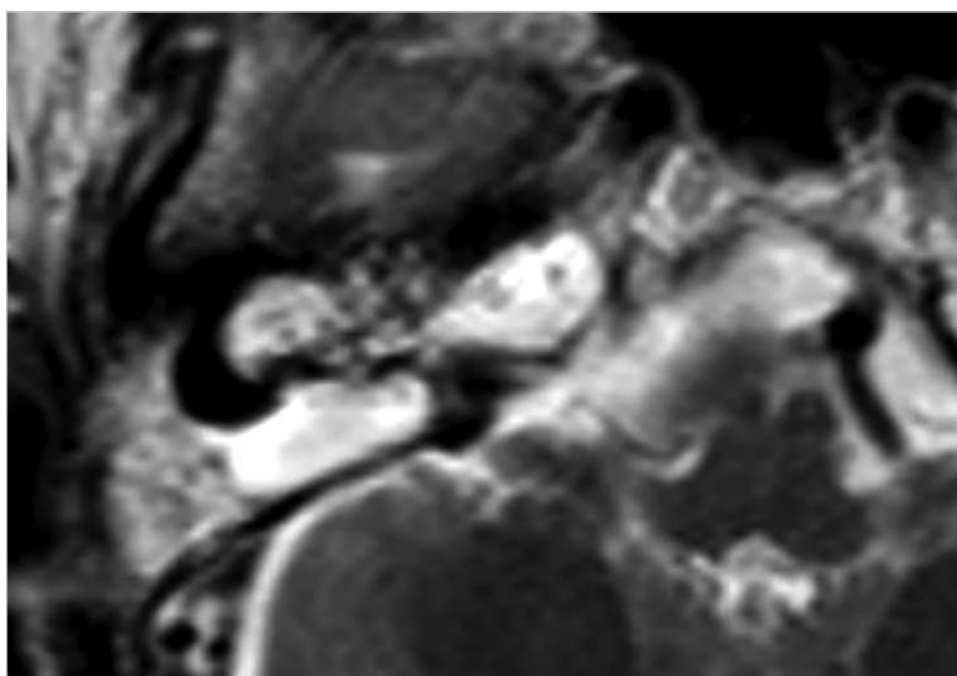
In T2-weighted image of MRI, extensive cholesteatoma filling the petrous bone is identified as a high-signal area.
